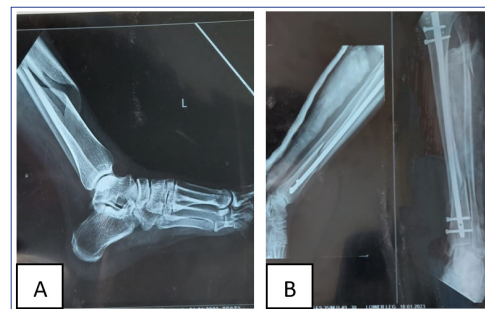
(A and B): Preoperative and Postoperative Radiograph Showing Fracture of Distal Tibia and Proximal Fibula Treated with Intramedullary Interlocking Nail.
